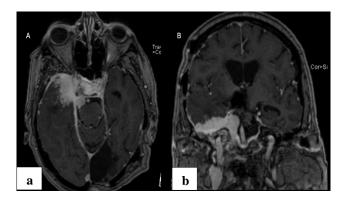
Aggressive meningioma (a and b) post-contrast T1-weighted axial and coronal images reveal a large, homogeneously enhancing, irregularly marginated extra-axial mass at the right central skull base and anterior temporal convexity. The mass demonstrates aggressive features with cavernous sinus invasion and ICA encasement (causing mild narrowing), trans spatial extension through the foramen ovale, and involvement of the sellar, suprasellar, and right prepontine regions. Associated mass effect displaces the right temporal lobe and compresses the right pons.
